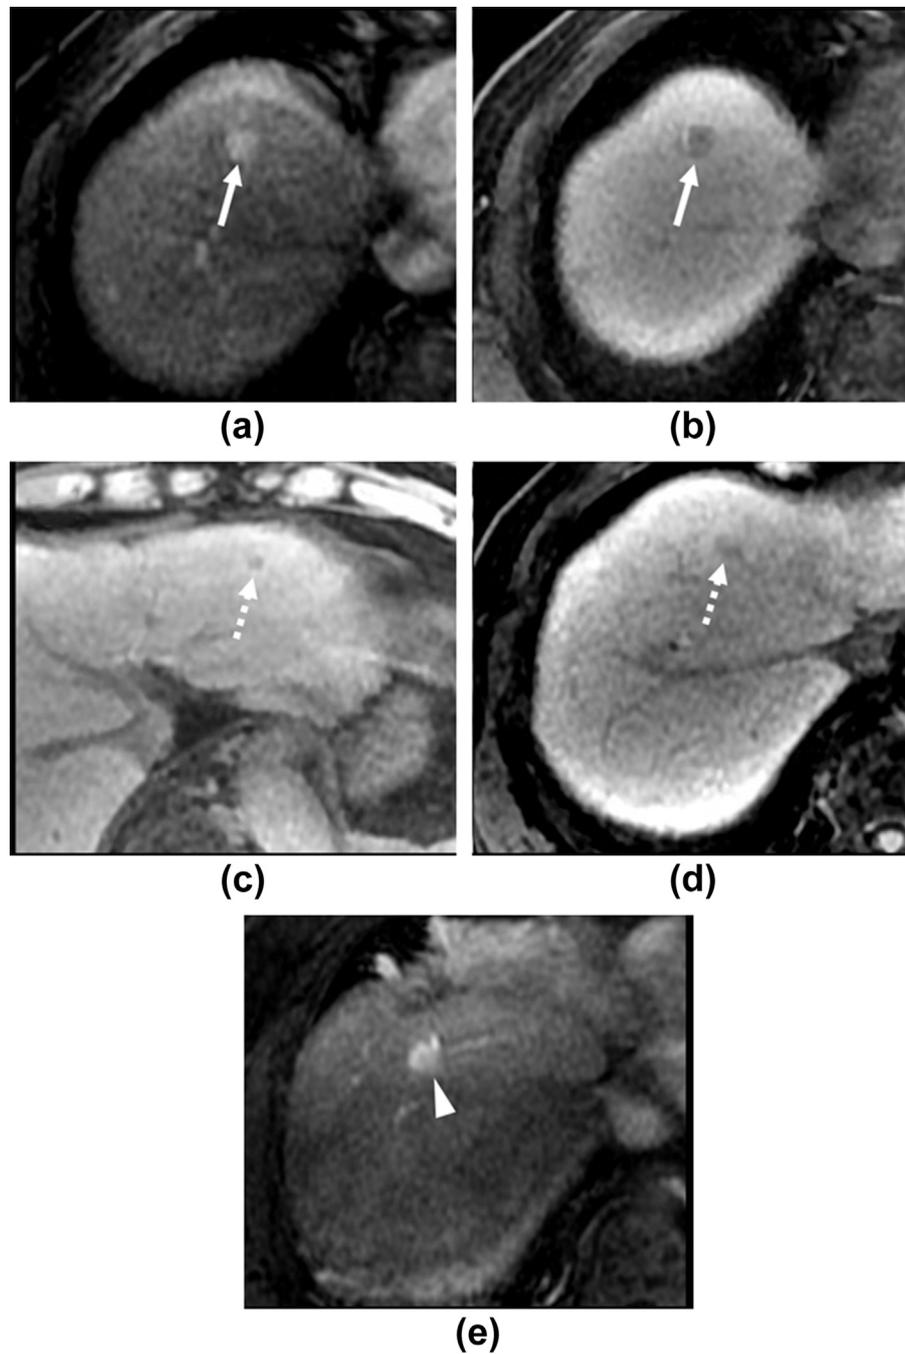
A case of small HCC with a HBP hypointense nodule without APHE that developed late recurrence. A 74-year-old man had a small hypervascular HCC (10 mm) at S8 (a, b, arrows). (c,d) Preoperative MRI images revealed HBP hypointense nodules without APHE (dashed arrows) in the liver. (e) One of the HBP hypointense nodules without APHE became a hypervascular HCC (arrowhead) 17 months after surgery (multicentric recurrence).
